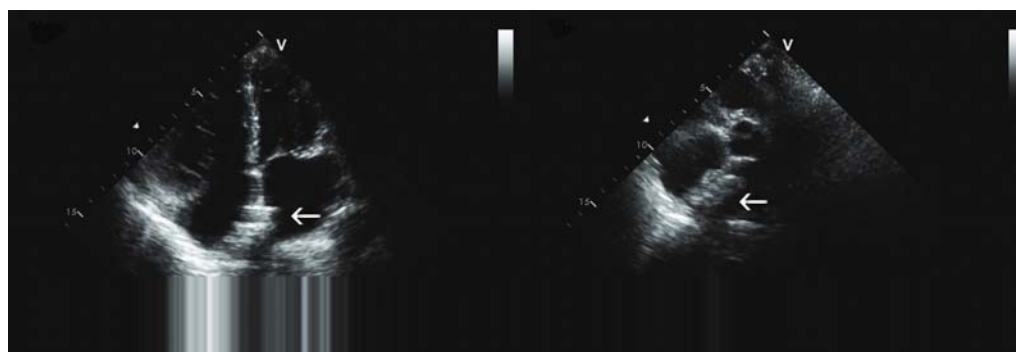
Transthoracic echocardiogram showing the good apposition of atrial septal defect occluder device on 6-month follow-up (arrows).
